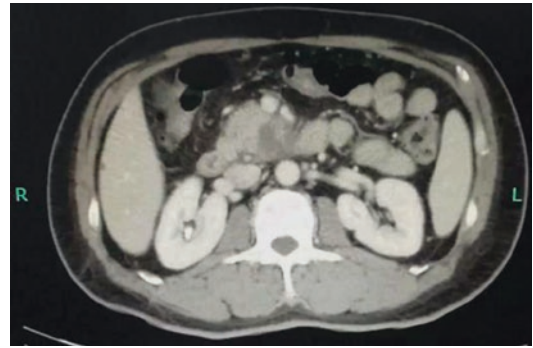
The CT showed a mass in the head of pancreas
